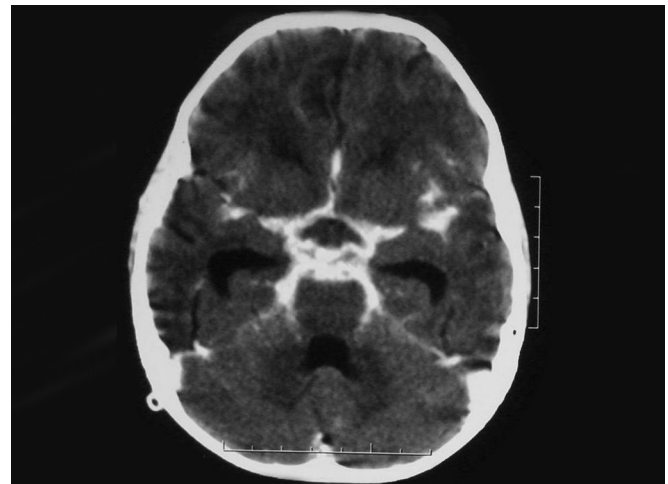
Axial contrast enhanced CT image of the brain at the level of basal cisterns shows densely enhancing exudates in all basal cisterns in tubercular meningitis
